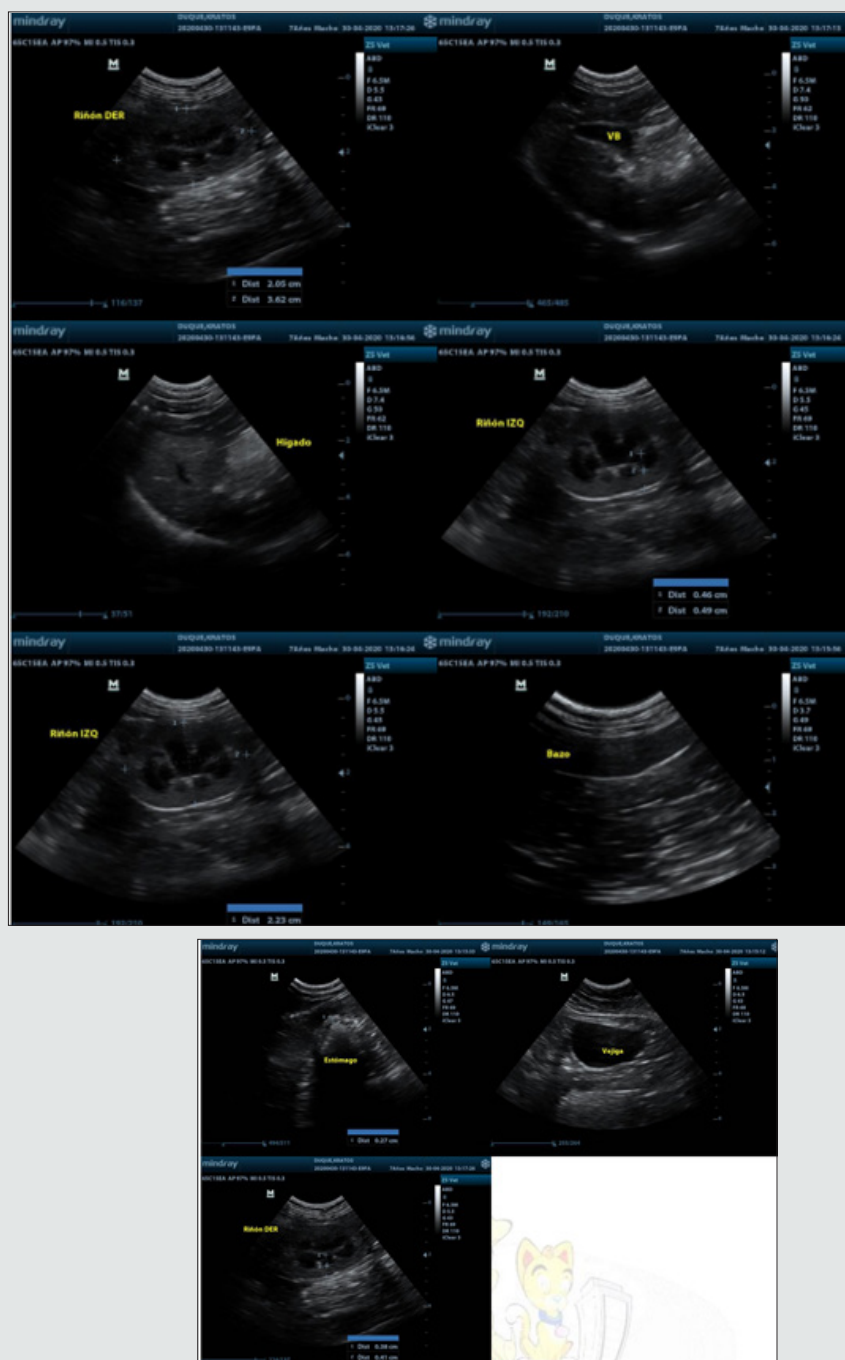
Complete abdominal ultrasound, kidney, bladder, liver, biliary vesicular, can be observed without pathological changes.
